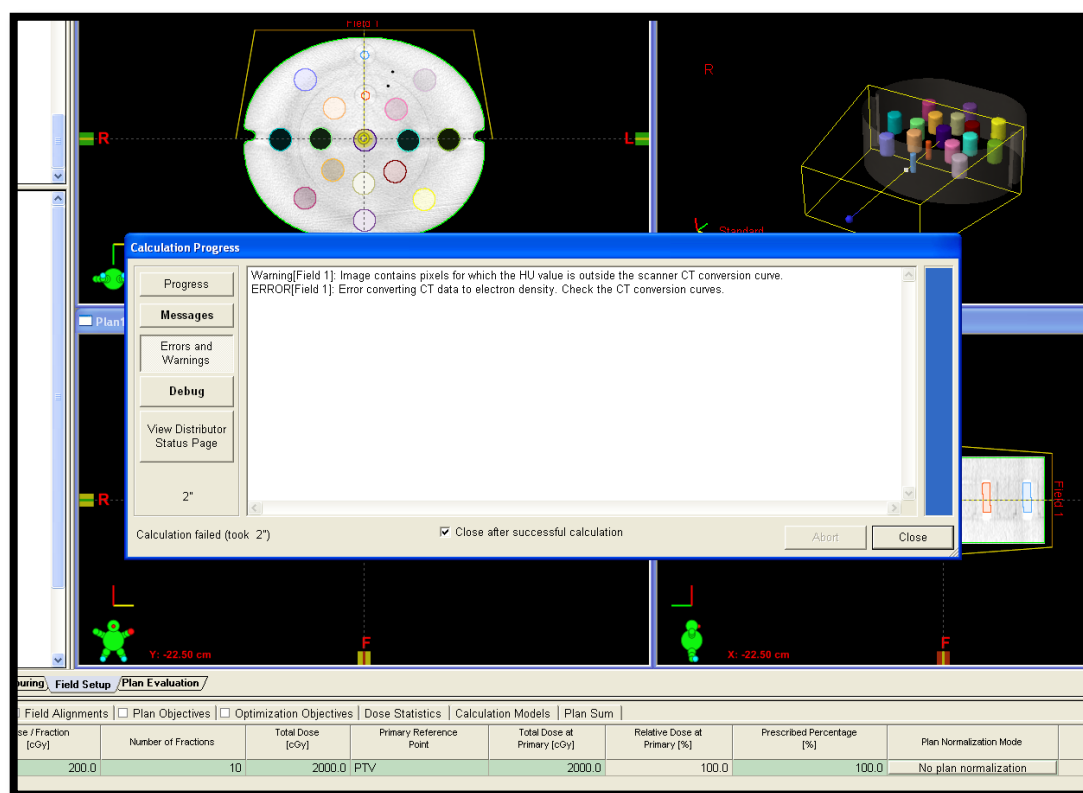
provides an example of using an incorrect calibration curve (M4-A-HS) for the pelvis area. The correct calibration curve is the M4-A-BP calibration curve, as shown in (Table 20, page 123). If the incorrect calibration curve is used, the differences between the CT and CBCT calibration curves may reach as much as 4.7 and 5.5% in CT and CBCT scan images respectively (Table 28).
